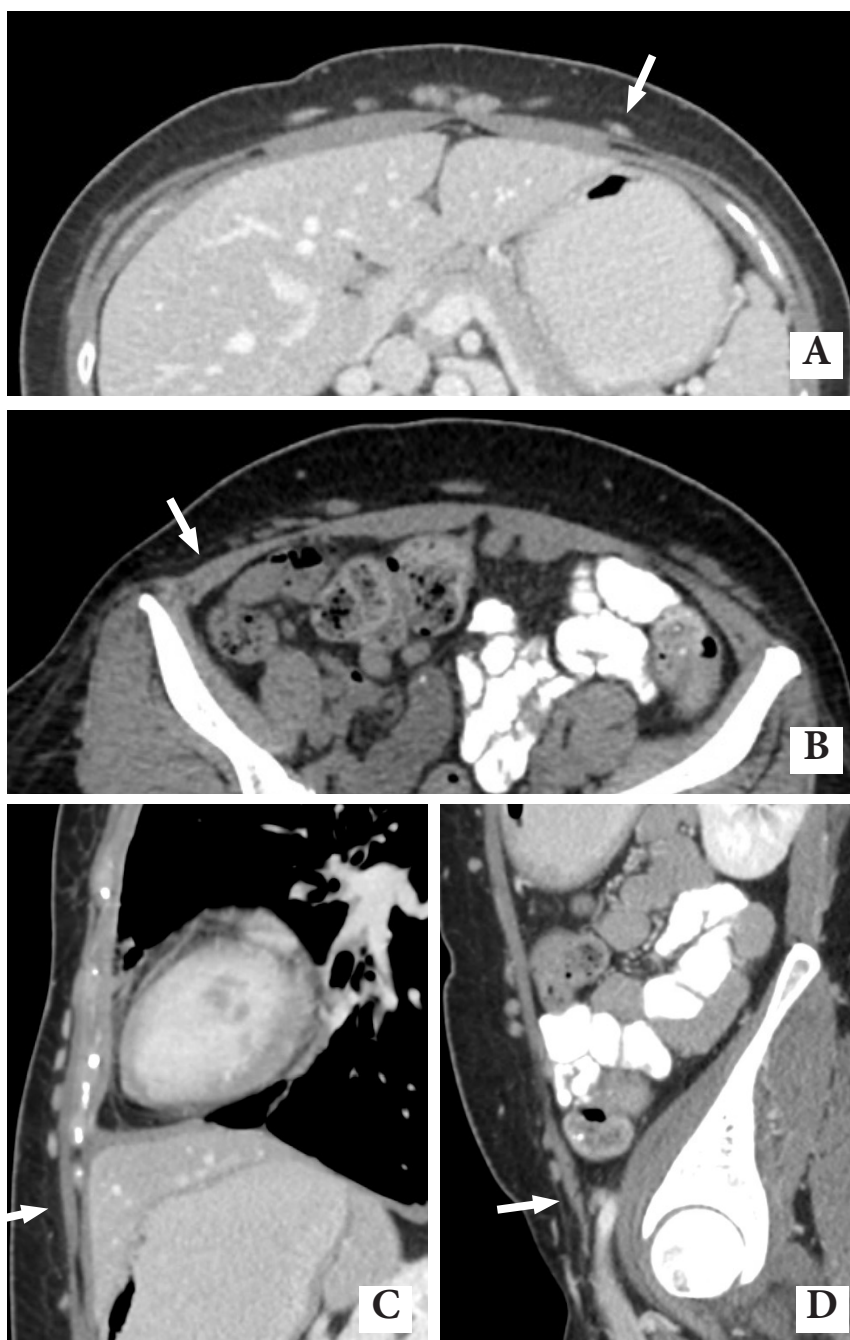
Conventional CT of the whole abdomen axial upper level (A), axial lower level (B), sagittal (C, D) show multiple well-defined enhancing nodules along the subcutaneous layer of the abdominal wall located beneath Camper's and Scarpa's fasciae (arrow).
